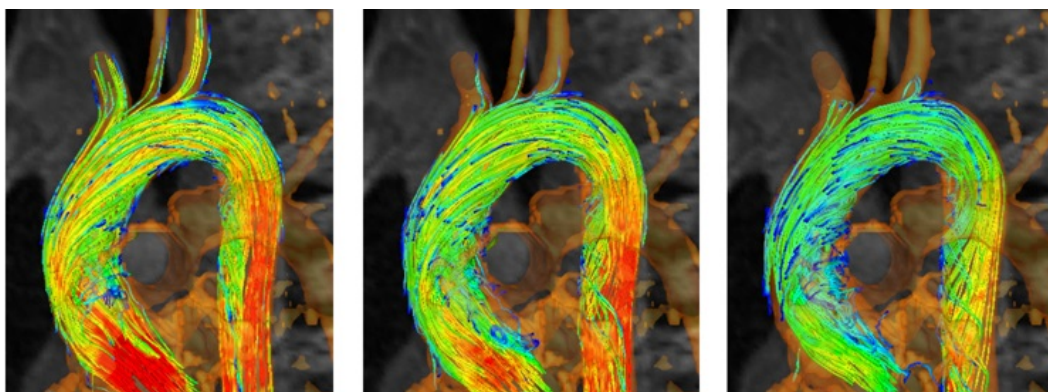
Estimated stream lines of the blood flow in the aortic arch measured using an MRI phase contrast sequence. Blood flow is shown for 140 ms (left), 180 ms (middle) and 220 ms (right) after the beginning of the cardiac systolic phase. (Image modified according to [Markl 11])
